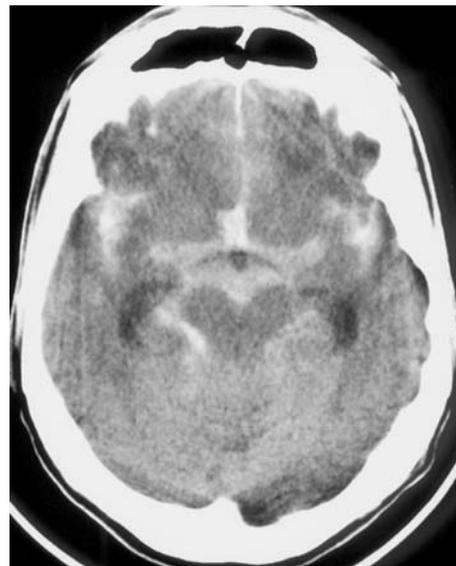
CT reveals massive basal subarachnoid hemorrhage and dilated temporal horns of the lateral ventricles
